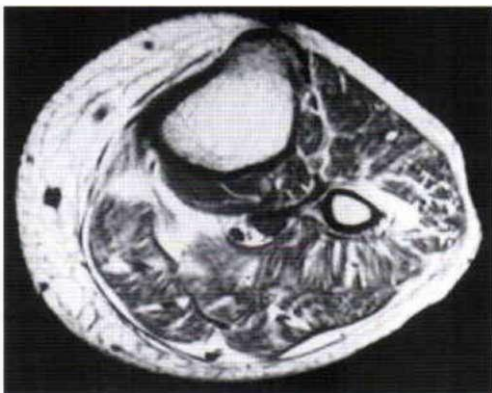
Transverse MR image of case 4 at 50% level
